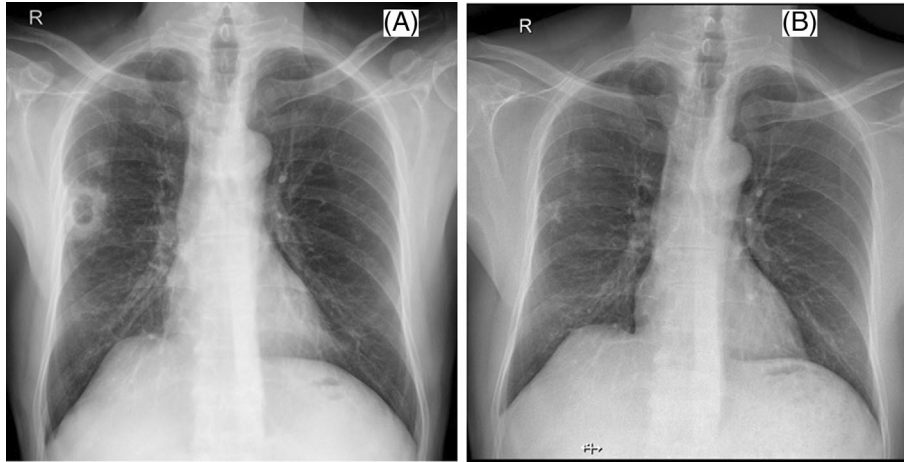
(A) Chest radiograph showing right middle zone cavity with fluid level and surrounding consolidation. (B) Post-treatment chest radiograph showing remnant fibrotic bands with near total resolution of the previous cavity.
